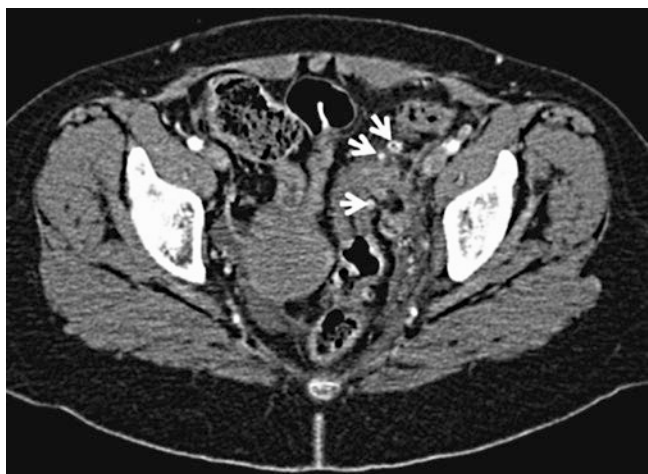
Axial CT of the pelvis demonstrating sigmoid diverticula with significant wall thickening of the sigmoid colon, consistent with acute sigmoid diverticulitis. *White arrows: diverticula*
